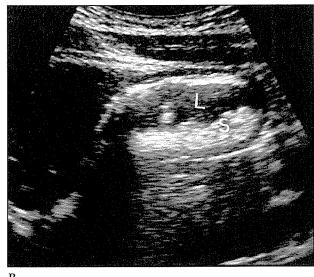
A, Longitudinal ultrasonogram of the gastric antral cross-sectional area (V) in a fasting healthy subject visualized by a scan passing through the abdominal aorta (AO) and the left lobe of the liver (HEPAR). The layers of the anterior abdominal wall (FAT, MUSCLE), the celiac trunk (TR C), and the superior mesenteric artery (SMA) also are shown. B, Postprandial longitudinal ultrasonogram of the gastric antral cross-sectional area in a healthy subject shows the liquid (L) and solid (S) parts of the gastric content.
